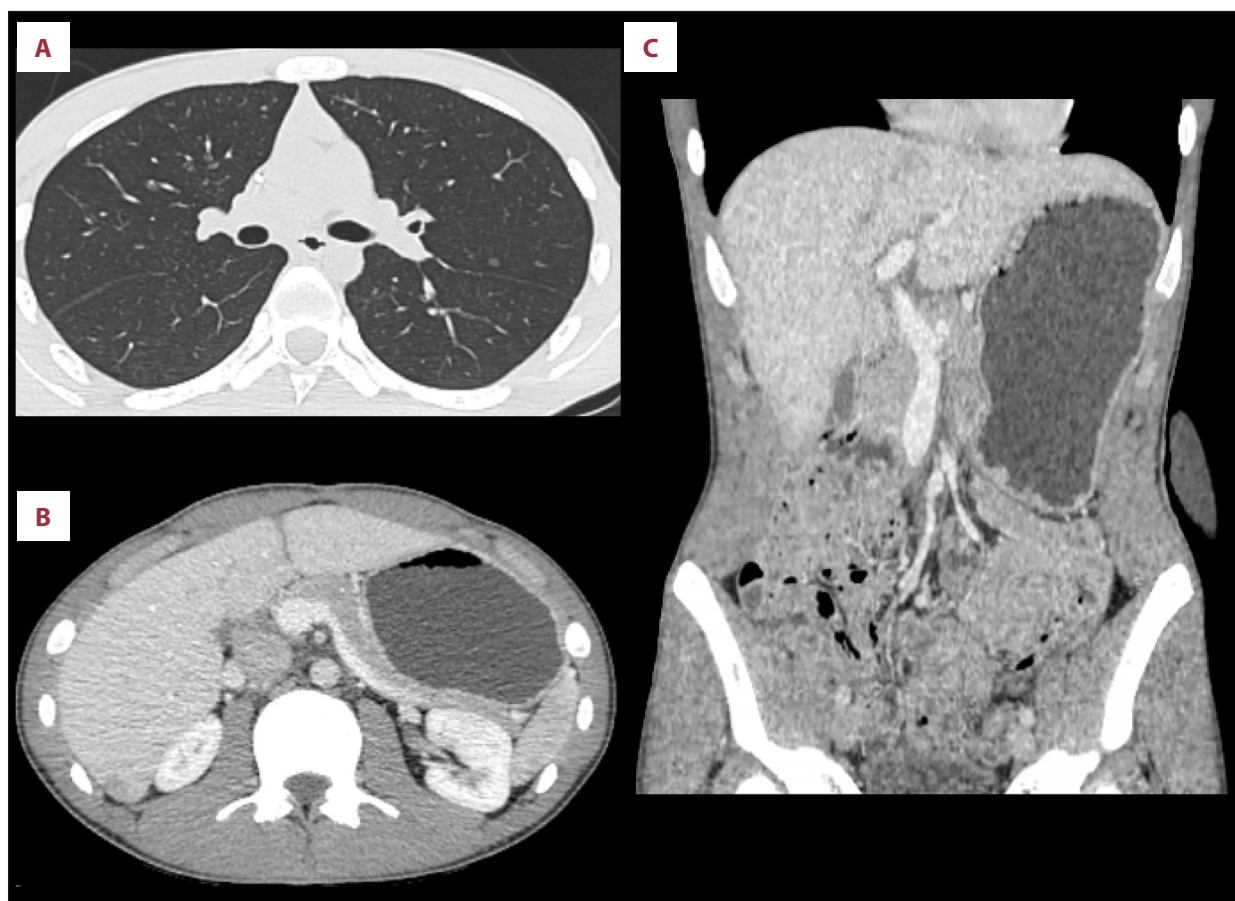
Surveillance imaging after restoration of intestinal continuity. (A-C) Follow-up computed tomography images demonstrating normal postoperative appearance after restoration of bowel continuity, without evidence of recurrent tumor, lymphadenopathy, or metastatic disease.
